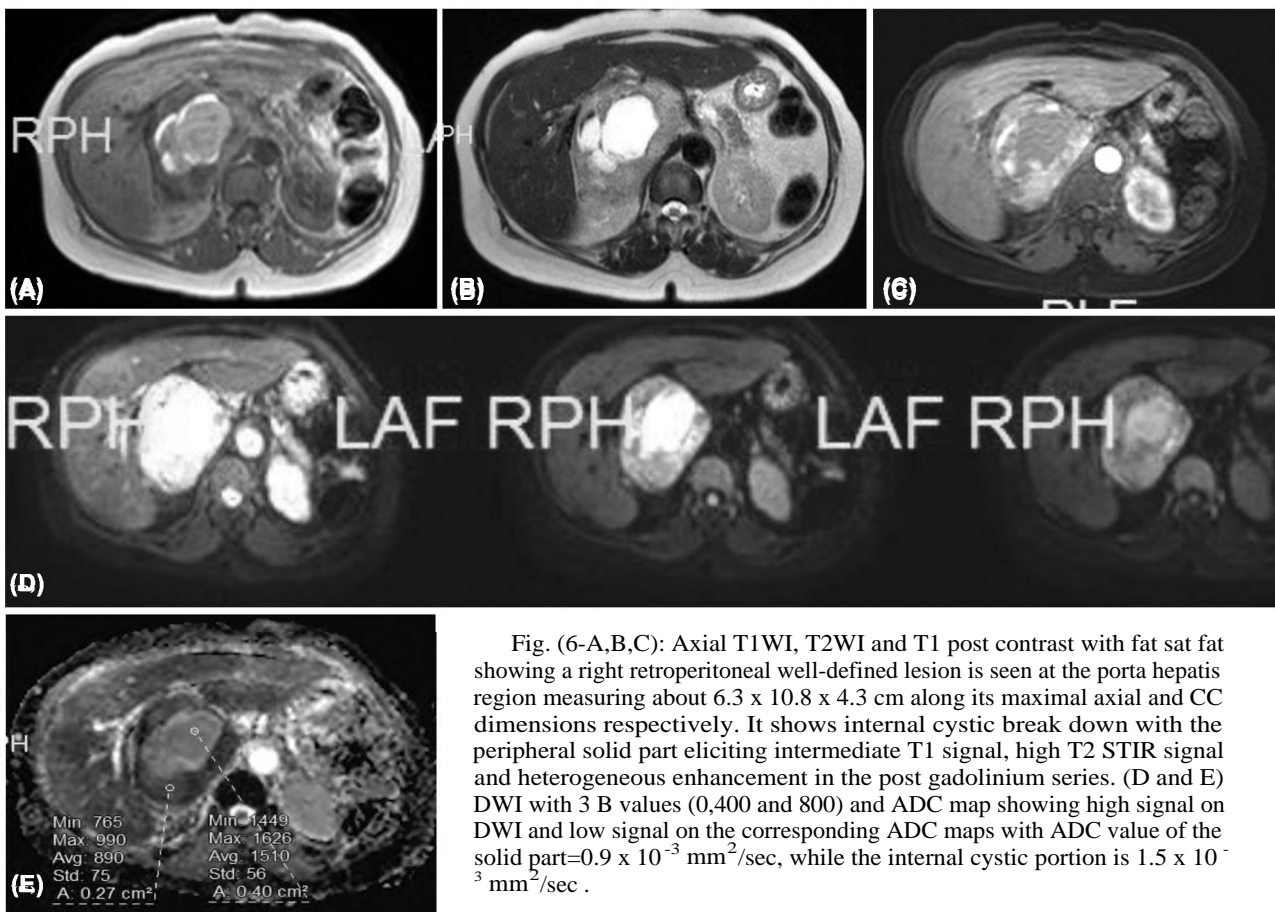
Axial T1WI, T2WI and T1 post contrast with fat sat fat showing a right retroperitoneal well-defined lesion is seen at the porta hepatis region measuring about 6.3 x 10.8 x 4.3 cm along its maximal axial and CC dimensions respectively. It shows internal cystic break down with the peripheral solid part eliciting intermediate T1 signal, high T2 STIR signal and heterogeneous enhancement in the post gadolinium series. (D and E) DWI with 3 B values (0,400 and 800) and ADC map showing high signal on DWI and low signal on the corresponding ADC maps with ADC value of the solid part= $0.9 \times 10^{-3} \text{ mm}^2/\text{sec}$, while the internal cystic portion is $1.5 \times 10^{-3} \text{ mm}^2/\text{sec}$.
